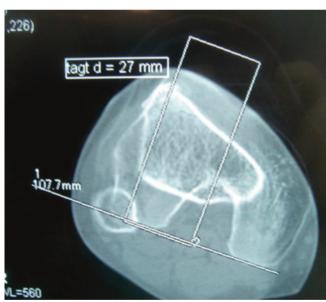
TT-TG distance measurement on CT scan = 27 mm
